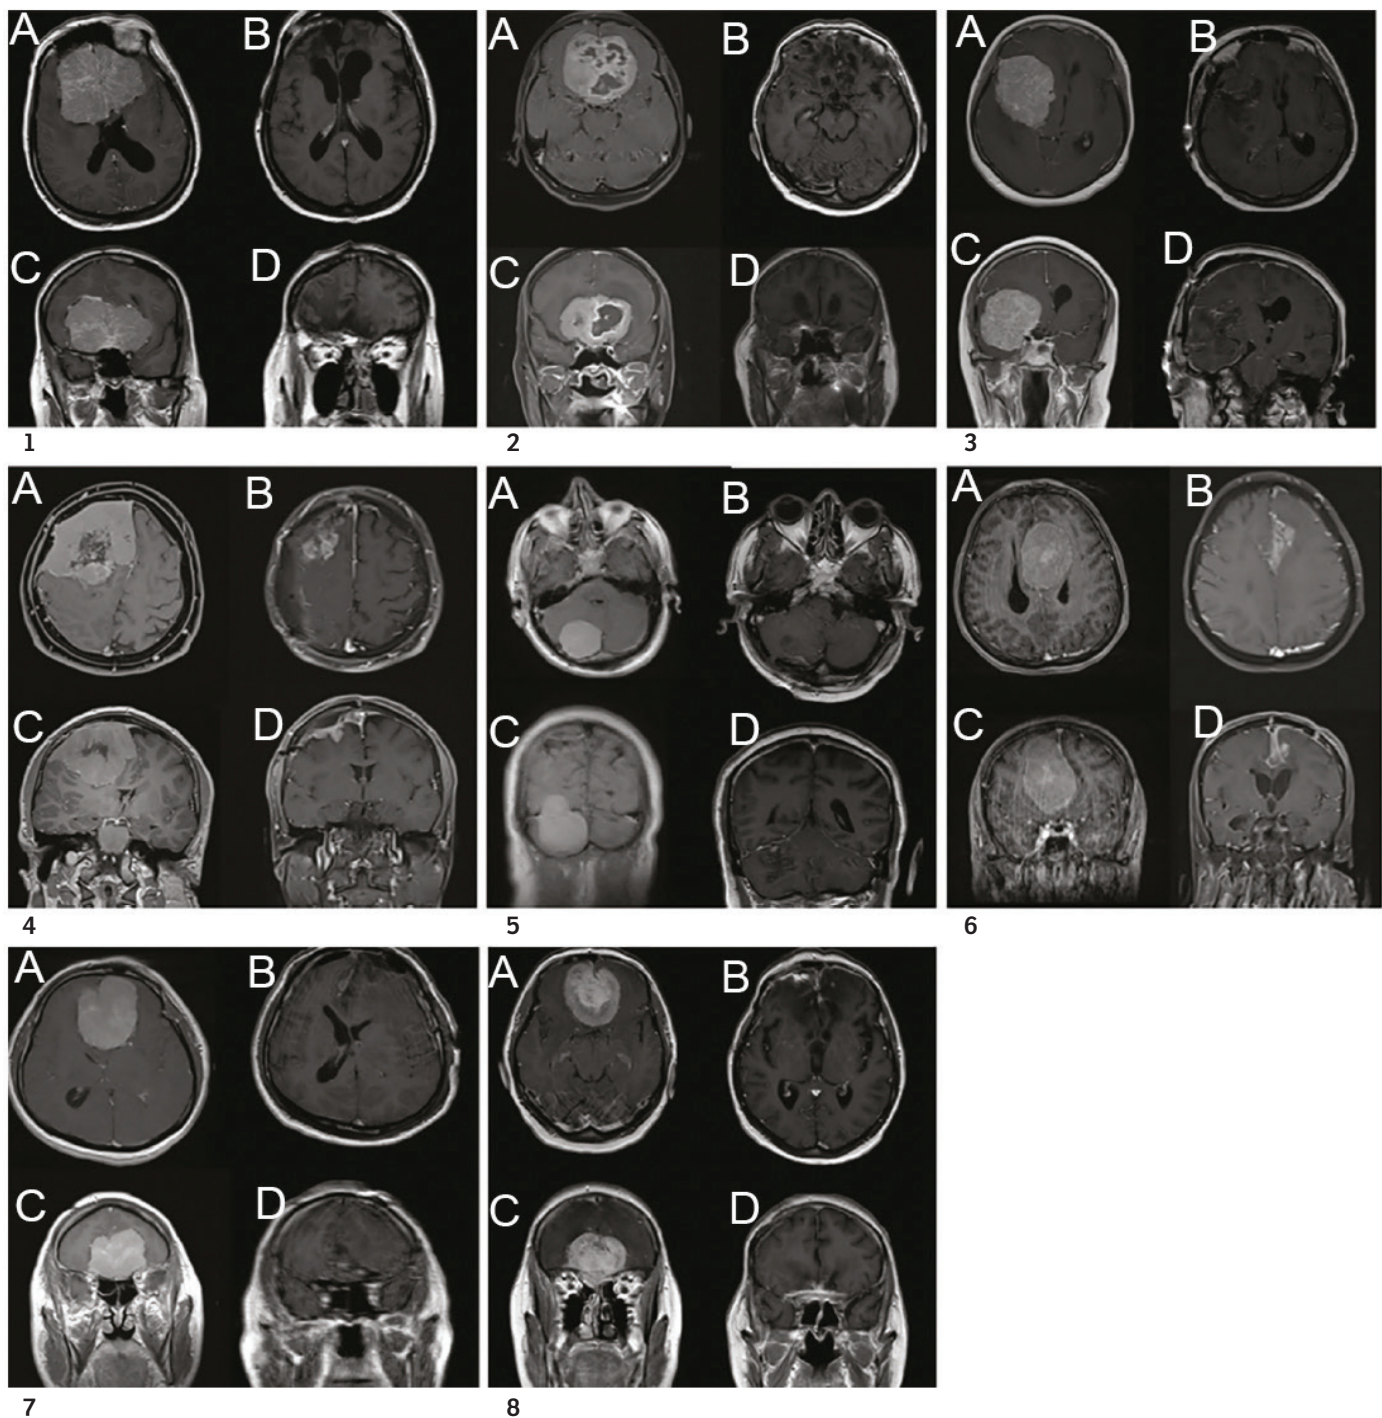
Pre- and post-operative contrast-enhanced MRI images of giant meningioma
